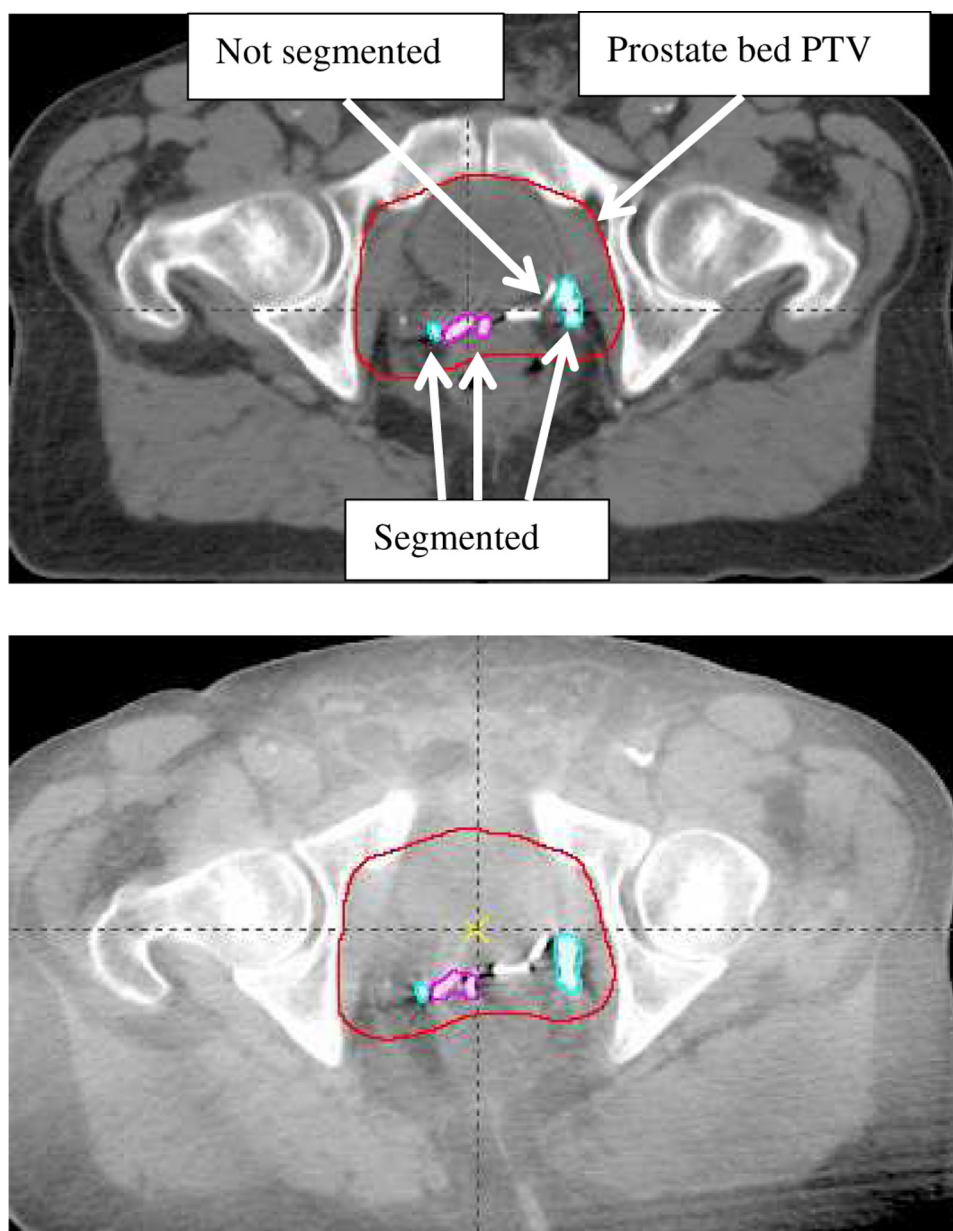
Axial view of one computed tomography slice through the prostate bed, showing the contoured segments of surgical clips on the treatment planning computed tomography scan and 1 cone beam computed tomography scan.
